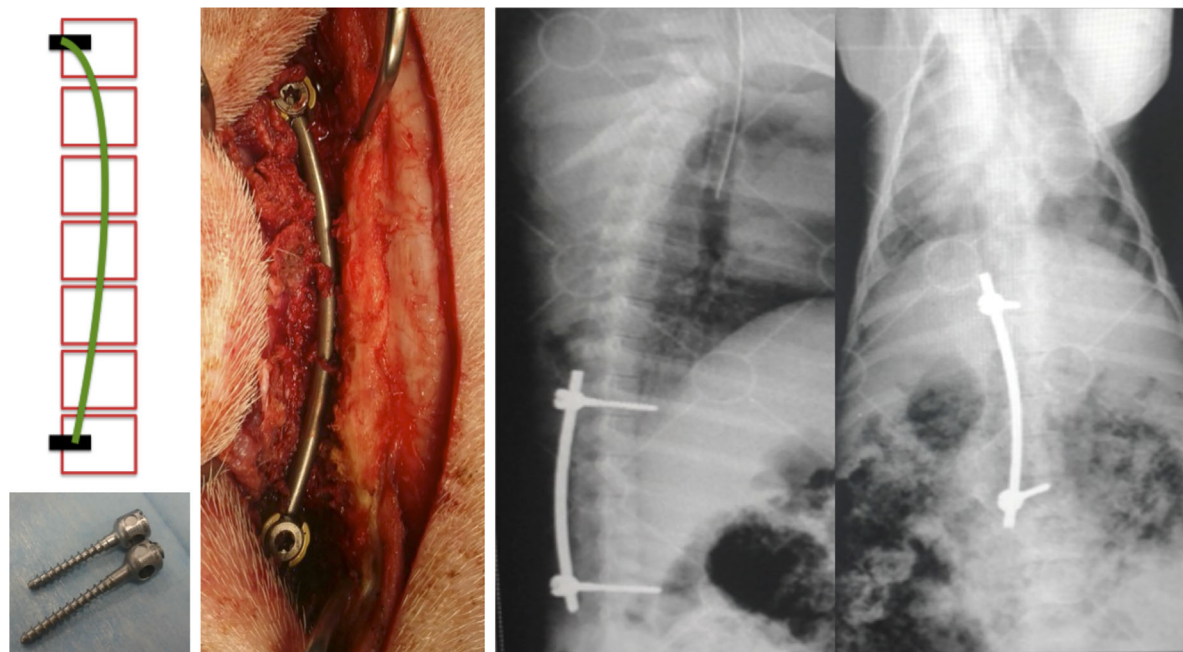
Experimental design of the surgical technique, detail of the pedicle screws, intraoperative setting of the instrumentation and post-op X-rays check-up of the final position of the screws and rod.
